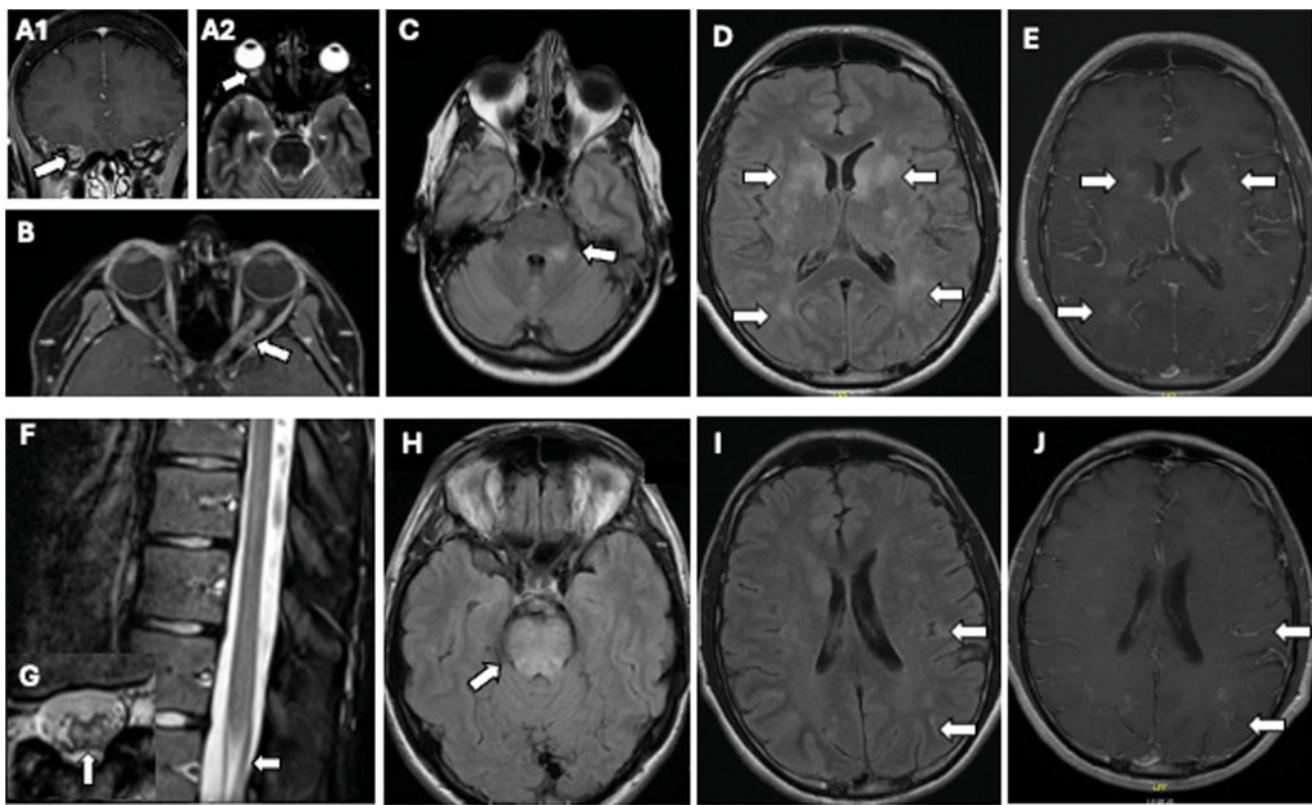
MRI scans highlighting features identified as either typical or suggestive of MOGAD. Examples of lesions (white arrows) associated with adult MOGAD patients. A1) Right perineural optic sheath enhancement (white arrows). A2) Radiologically visible right optic disc swelling. B) Left longitudinally extensive optic nerve hyperintensity. C) fluffy infratentorial lesion (left middle cerebellar peduncle). D) Large ill-defined T2-hyperintense lesions involving supratentorial white matter and deep grey matter with E) Gadolinium-enhancing lesions. F) Conus lesion. G) Central spinal cord involvement with H sign. H) Diffuse T2-hyperintense pontine lesion I) Cortical FLAIR-hyperintense lesions with J) Diffuse leptomeningeal gadolinium-enhancing lesions.
